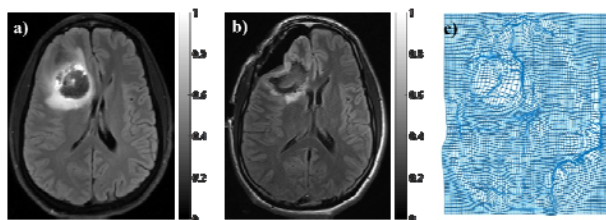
(a) Pre-operative MR image, (b) Intra-operative MR image, (c) Brain deformation field was achieved by registration of intra-operative and pre-operative MR images using residual complexity method.
